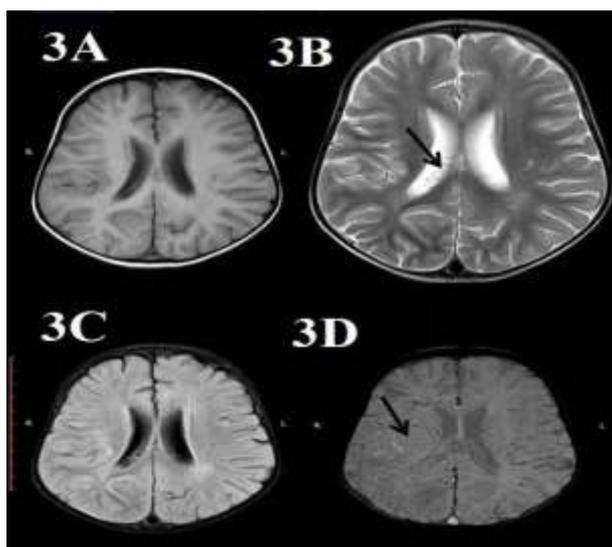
MRI brain, T1W axial image demonstrates few punctate hypointensities in white matter. Fig. 3B: MRI brain, T2 weighted axial image shows subtle subcortical white matter hyperintensities with ipsilateral prominent vessels in choroid plexus (as shown with arrow). Fig. 3C: MRI brain, FLAIR axial image shows subtle subcortical white matter hyperintensities. Fig. 3D: MRI brain, FLAIR axial image shows subtle subcortical white matter hyperintensities (as shown with arrow)
